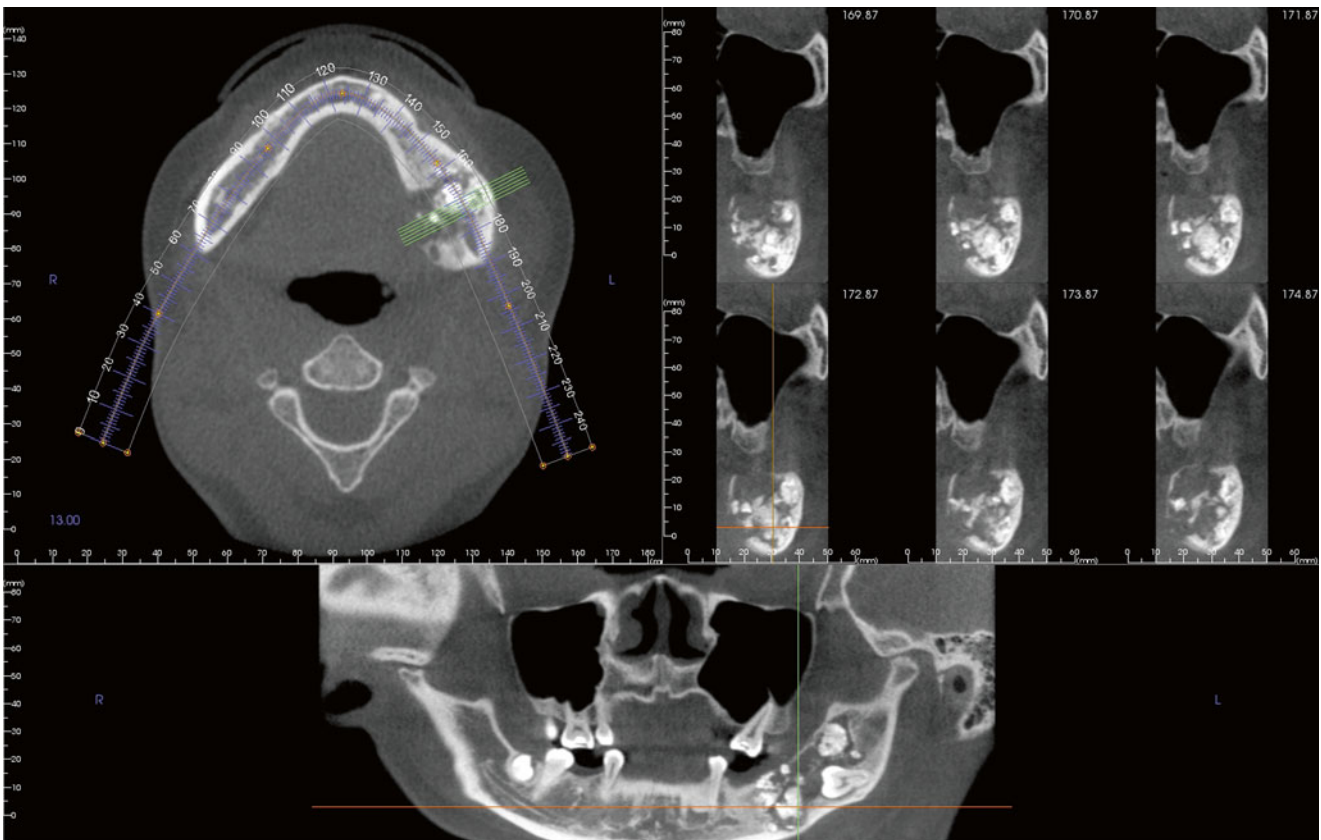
Standard CBCT cross-sectional images of the tumor shown in Figs. 6.16 and 6.17
